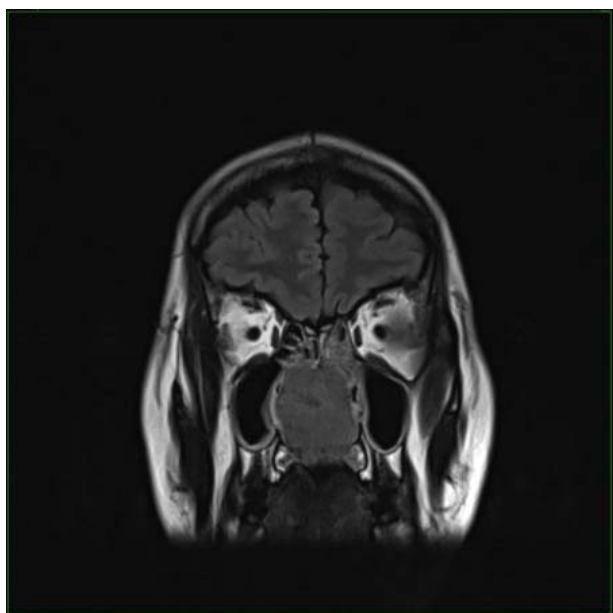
MRI (coronal) showing the septal mass with multiple areas of cystic degeneration, occupying both nasal cavities.
